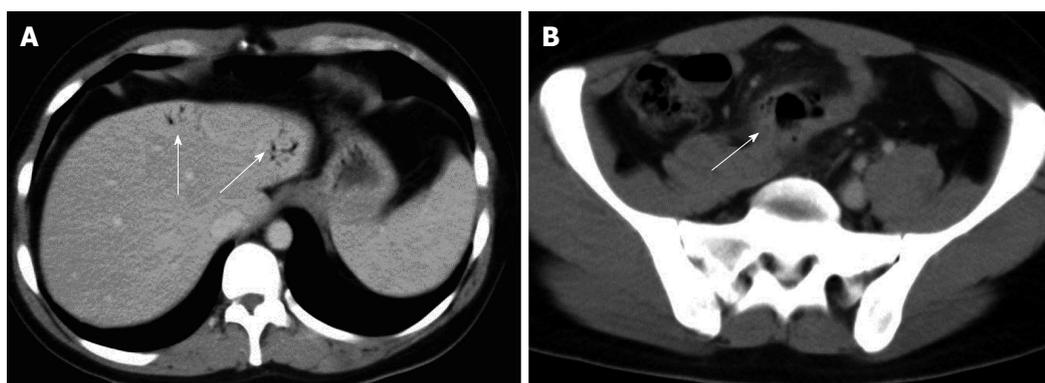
Intrahepatic portal air from diverticulitis. A: Computed tomography transverse scan shows the presence of intrahepatic portal air (arrows); B: Pelvic sigmoid diverticulitis complicated by peridiverticular abscess (arrow).
